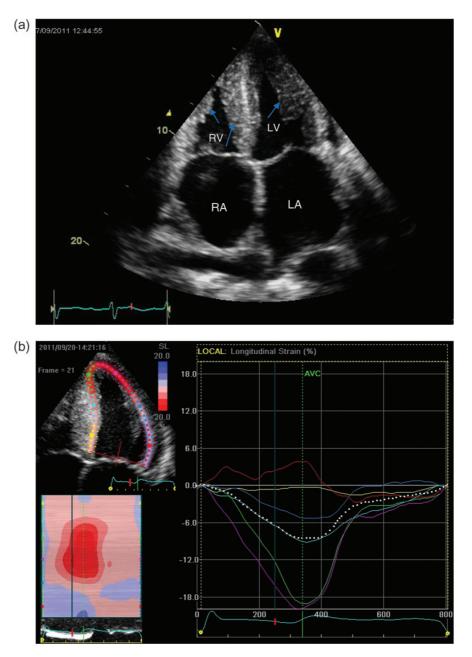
Echocardiography in cardiac amyloidosis. (a) Two-dimensional echocardiography in a patient with advanced cardiac amyloidosis demonstrating the thickening of the interventricular septum, LV free wall as well as the right ventricle (-->). There is bi-atrial enlargement giving an 'owl's-eye' appearance to the images. (b) Transthoracic echocardiogram with speckle tracking in a patient with cardiac amyloidosis. The LV wall is divided into six segments and the movement of the myocardium is tracked. This demonstrates that the base of the heart is affected to a much greater extent with limited contractile movement (red and yellow lines) compared with the apex (purple and green lines). On mapping, this demonstrates a characteristic 'bulls-eye' appearance (left lower image), which is rare in patients with other hypertrophic cardiomyopathies.
